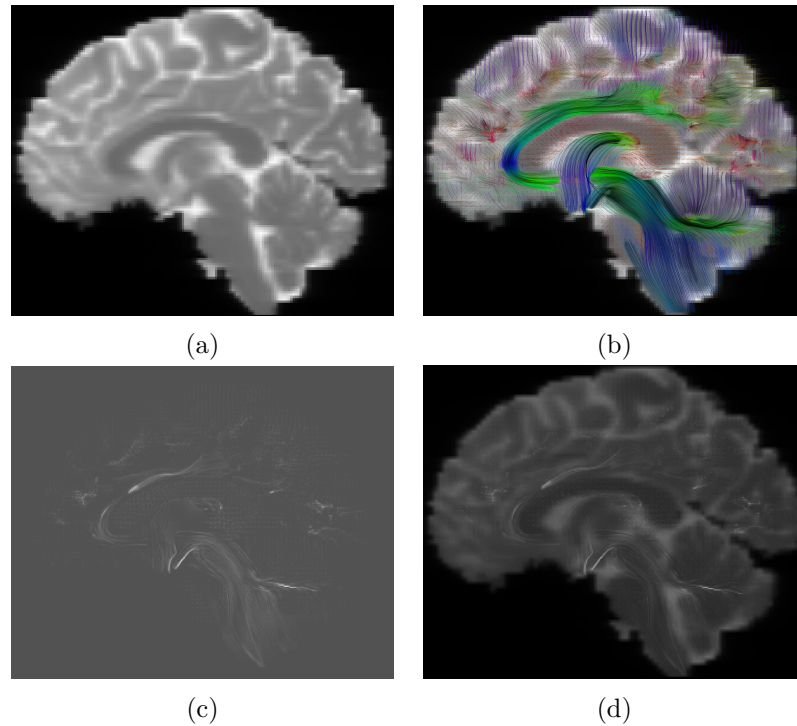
Linear combination of anatomical MR and track density images: (a) Anatomical MR image, (b) MR image superimposed with the 3D fiber tracks, (c) Track density image, (d) Linear combination of (a) and (c).
